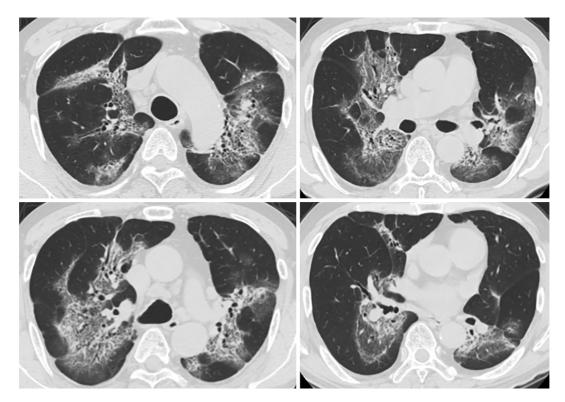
CT findings at the first visit to our hospital. Ground-glass opacities (GGOs) with a peribronchial distribution were predominantly observed in the upper lung.
